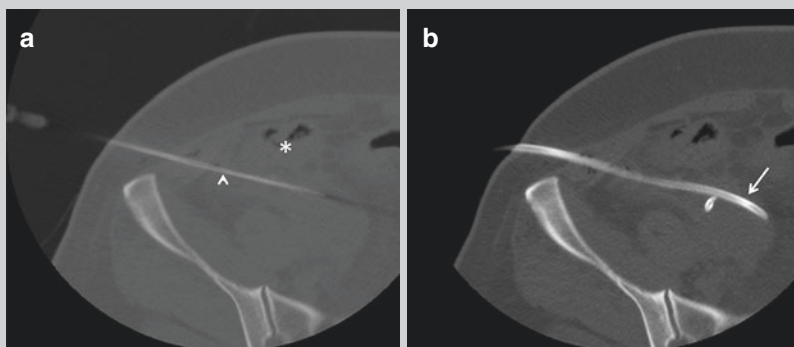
(a) A needle (*arrow-head*) is advanced into the abscess under CT guidance using intermittent acquisitions. Note the safe access route behind the caecum (*asterisk*). (b) Final CT demonstrating the pigtail drain within the abscess (*arrow*)
